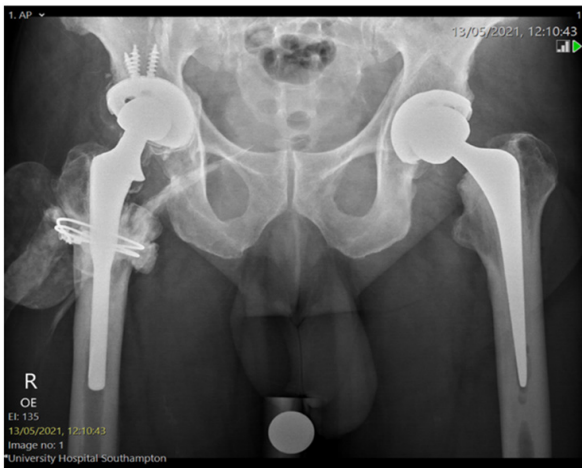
Pre-operative x-ray, note the metallosis shadow lateral to the femoral stem and the proximal osteolysis.
